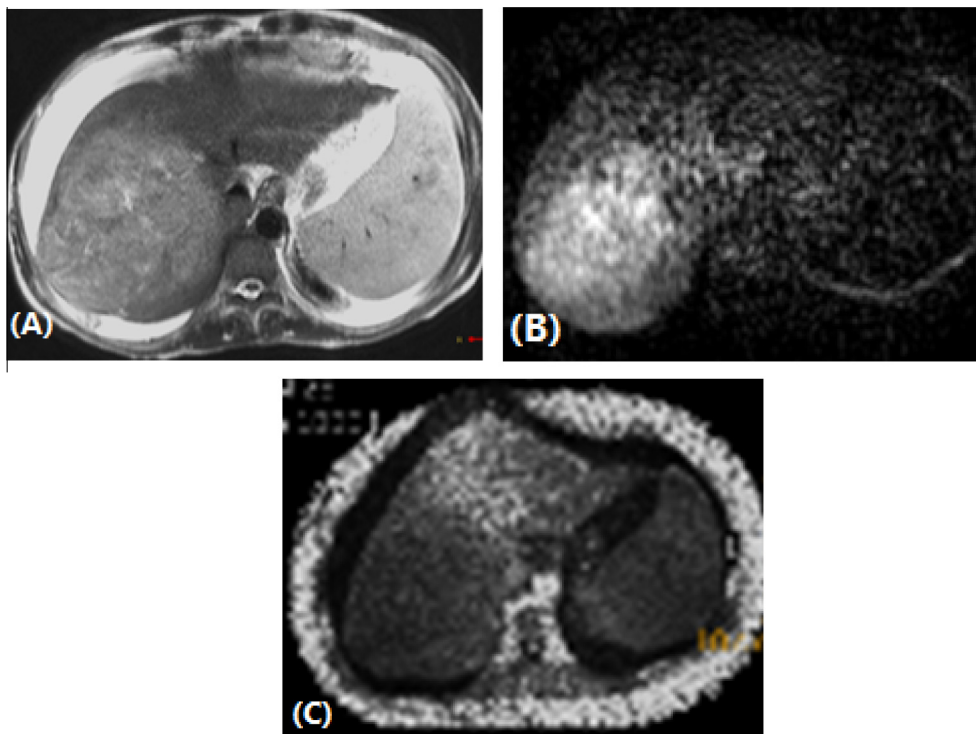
HCC in liver cirrhosis in a 45 year-old female patient. (A) Axial T2-weighted image shows moderately hyperintense right lobe large lesion. Note the associated ascites. (B) DWI (*b* = 600) image shows the hyperintensity of the lesion. (C) ADC map shows hypointense lesion with low ADC value ($0.98 \times 10^{-3} \text{mm}^2/\text{s}$).
